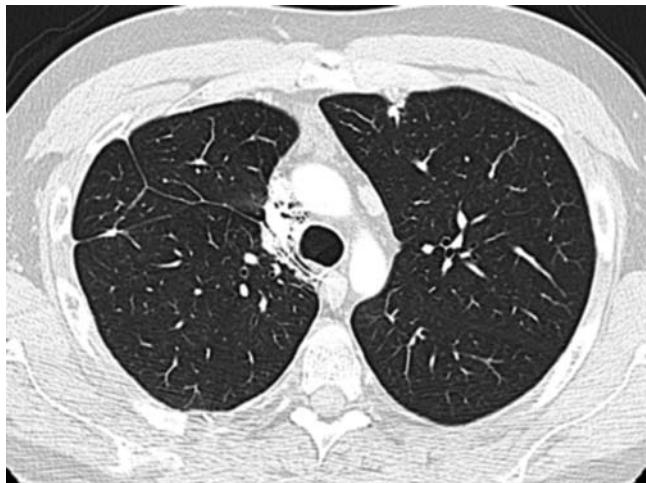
CT of chest showing a small pleural-based opacity in the left upper lobe. Biopsy showed a metastatic osteosarcoma.
